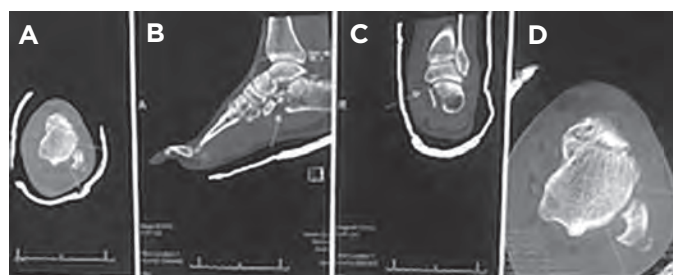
A) Axial, B) sagittal, C) coronal (posterior facet), and D) expanded axial computed tomography cuts of the left ankle. The triangle shows peroneal tendons (brevis and longus) trapped between distal fibula and avulsed fragment. Circle shows a talar neck fracture. The arrow shows a comminuted anterior calcaneus fracture.
